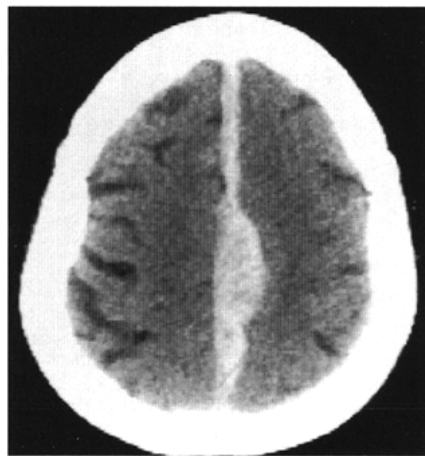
CT without contrast at admission showing an ISH on the left side.
